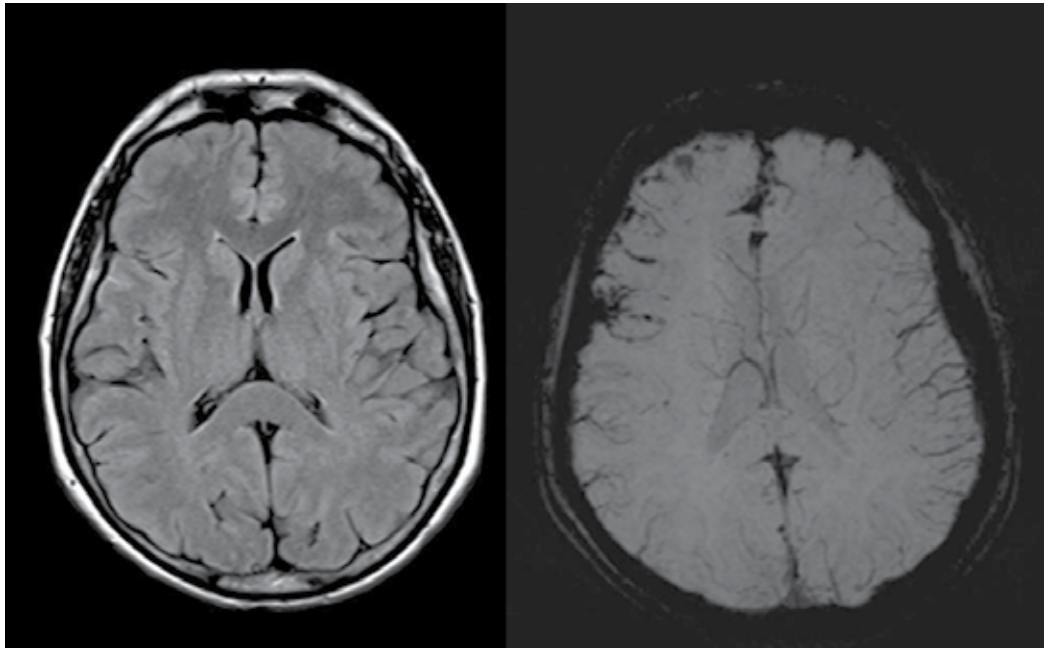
In the case that has been brought to the emergency room with such an intensive headache that he could bump his head on the wall, FLAIR sequence image sensitive to the lesion and pathology showed no abnormality; however, axial section from SWI sequence showed signal loss in the right extra-axial spaces due to the presence of hemorrhagic products.
